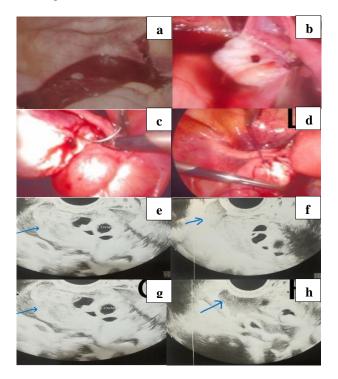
(a-d) Showcase the intra-operative images, (a) hemoperitoneum, (b) active bleeding from puncture site, (c) haemostatic sutures, and (d) after suturing); (e-h) showcase the pre-operative ultrasonographic images, (e and f) hematoma and hemoperitoneum (2.4×2 cm peri-ovarian hematoma, with MVP-2 cm collection near right ovary on day 2), and (g and h) hematoma and hemoperitoneum (2.6×1.8 cm hematoma, with MVP-1.5 cm collection near the right ovary on day 3).
